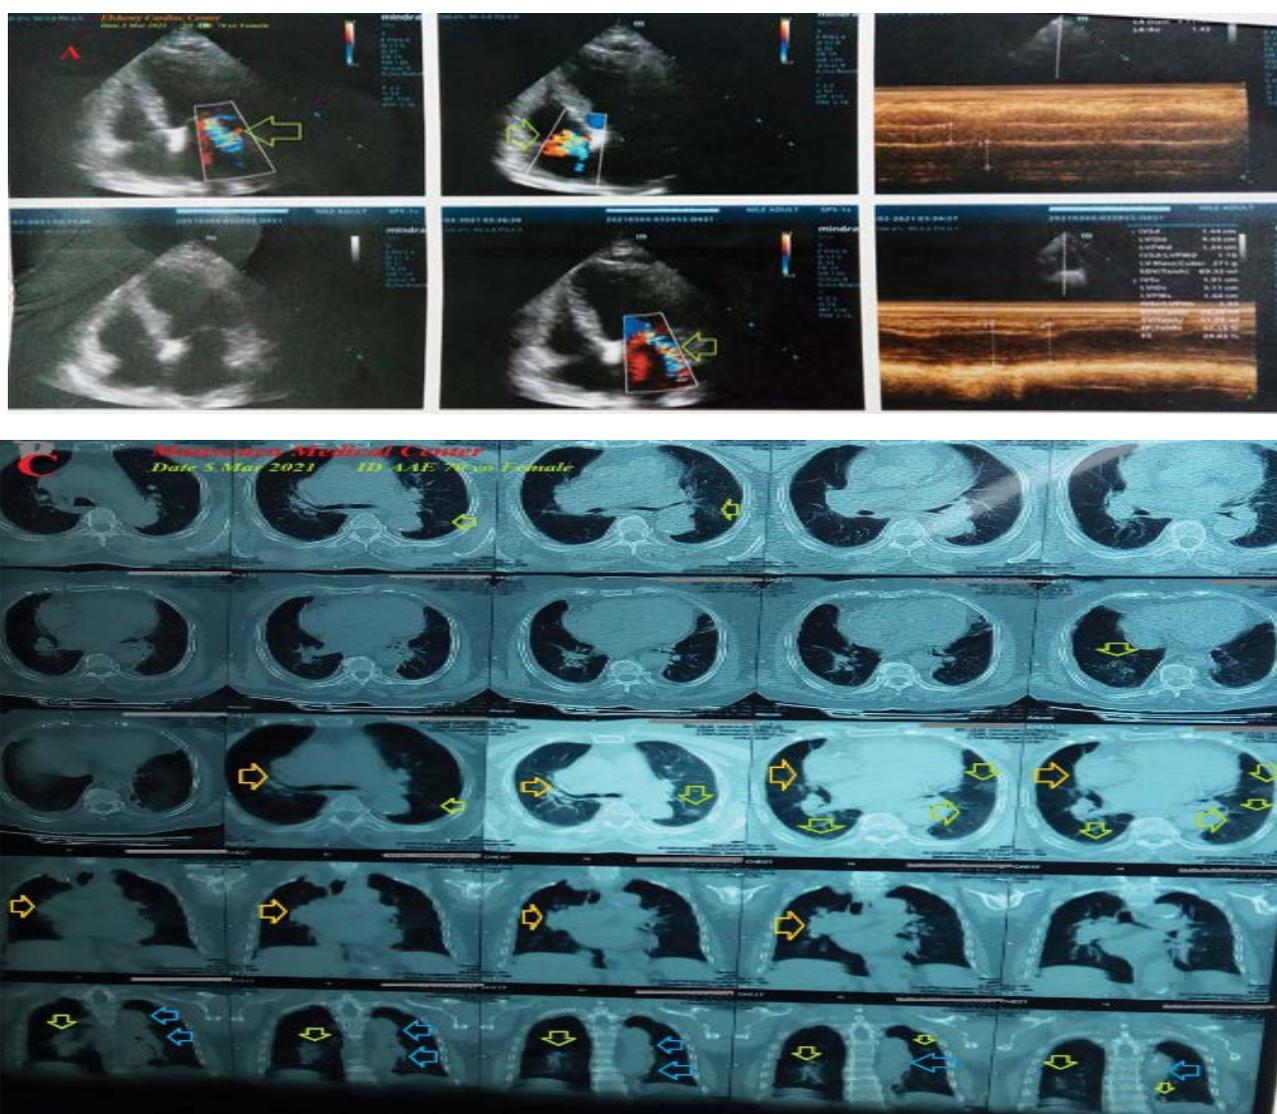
(A). The echocardiography was done on the presentation showing mitral regurgitations with EF of 57%. (B). The plain CXR was done on the day of the presentation showing enlargement of both pulmonary arteries and shadow of right ventricular enlargement (C). The initial chest CT was done on the day of the presentation showing bilateral variable-sized ground-glass opacities (lime arrows), enlargement of both pulmonary arteries (blue arrows), and shadow of right ventricular enlargement (orange arrows).
